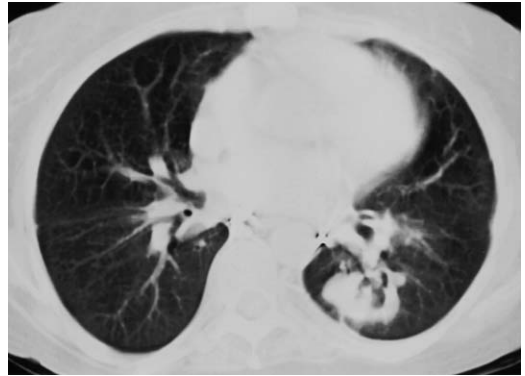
A 45-year-old woman status post heart, lung, and liver transplantation for primary biliary cirrhosis and pulmonary hypertension. CT scan shows a mass in the left lower lobe that contains dilated bronchi. Biopsy of the mass showed malignant lymphoma consistent with posttransplant lymphoproliferative disorder.
